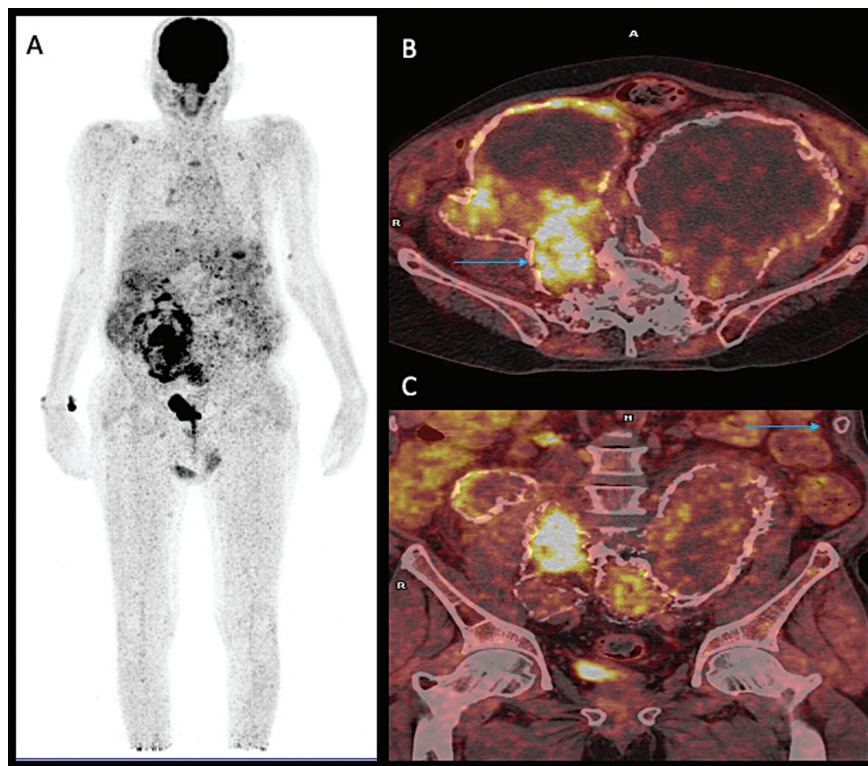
$^{18}\text{F}$ -FDG PET/CT. (A) Maximum intensity projection image of the whole body. (B) Transverse axial section showing large FDG-avid ( $\text{SUV}_{\text{max}} -9.9$ ) abdominal/pelvic masses with necrosis and calcification (blue arrow). (C) Coronal section showing FDG avid (red arrow) and nonavid lytic skeletal lesions (blue arrow). CT, computed tomography; PET, positron emission tomography; SUV, standardized uptake value.
